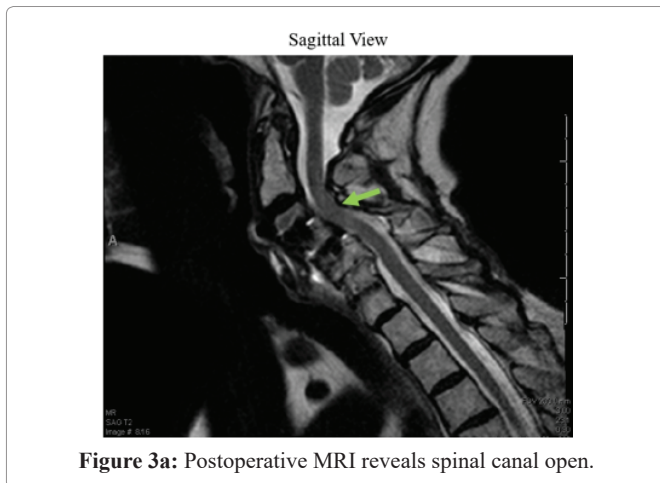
Postoperative MRI reveals spinal canal open.
